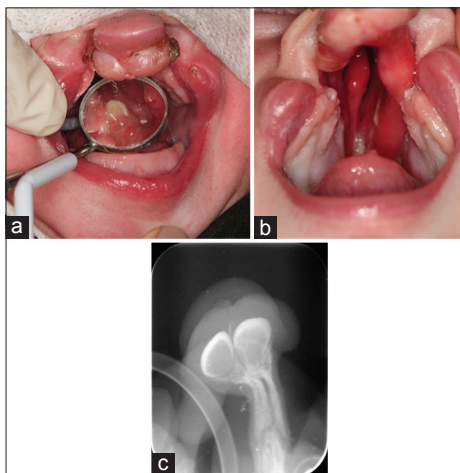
A male case with bilateral complete cleft lip and palate. (a) Intraoral view of neonatal teeth on cleft-side palatal region, 12-day-old. (b) Intraoral view after extraction, 20-day-old. (c) Intraoral radiograph to determinate soft tissue extension
